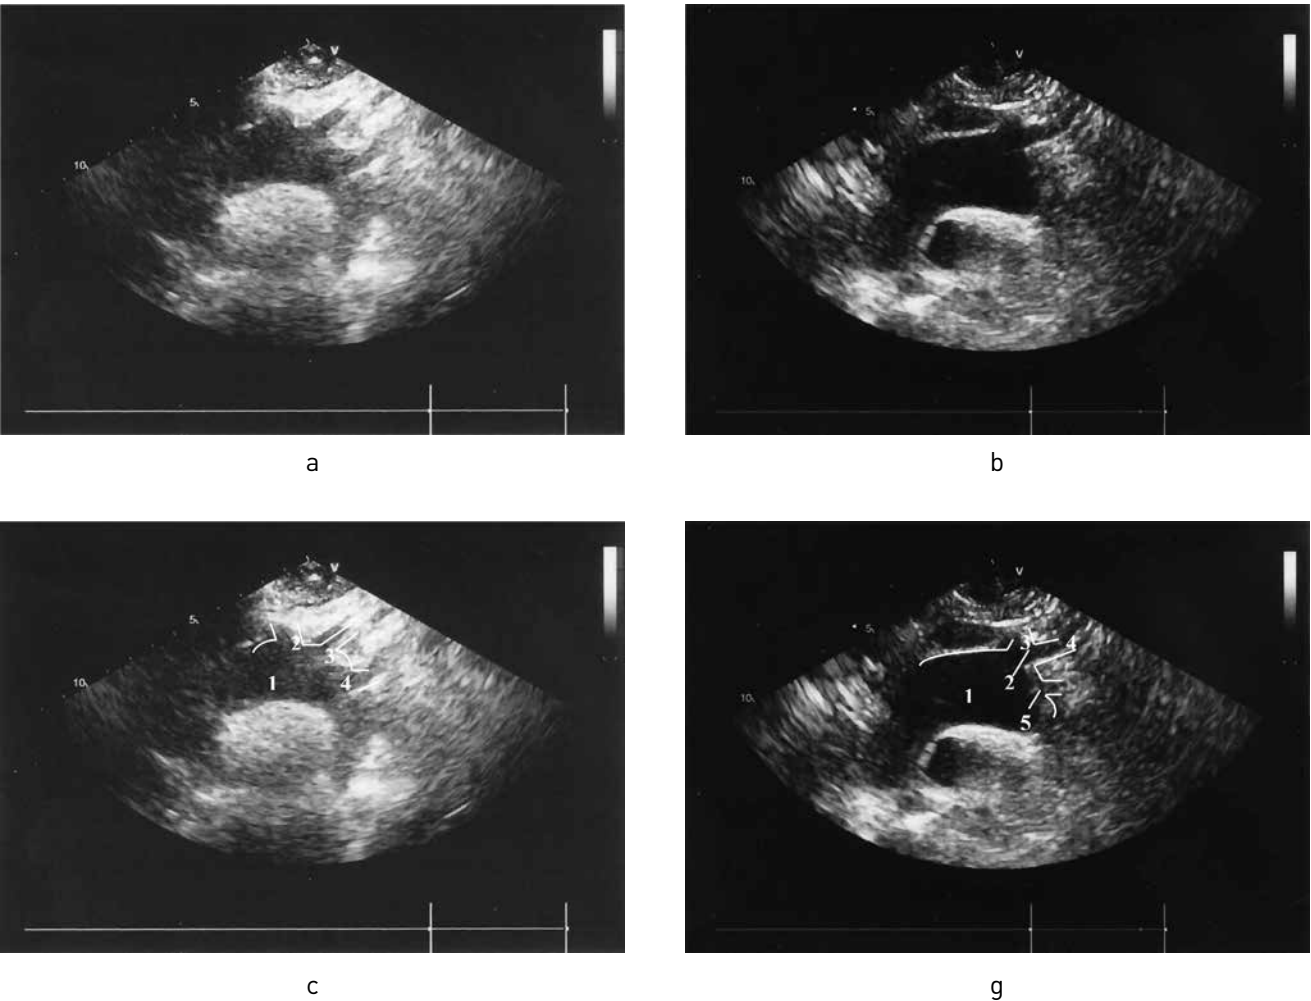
Suprasternal view echocardiograms showing aortic arch branches: a, c — in a healthy individual (1—aortic arch, 2—brachiocephalic trunk, 3—left CCA, 4—LSCA); b, g—in our patient (1—aortic arch, 2—common trunk of the right and left CCA, 3—right CCA, 4—left CCA, 5—LSCA)
